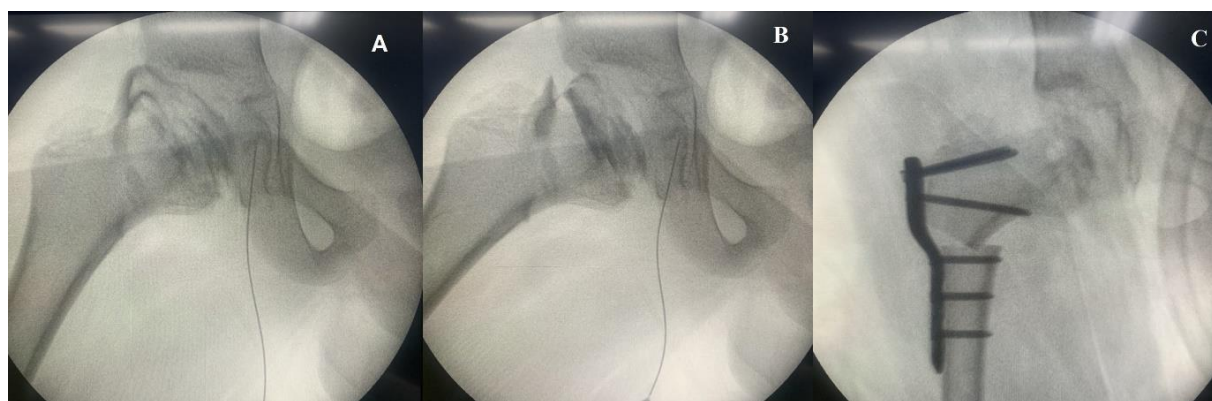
(A) Arthrogram showing lateral subluxation findings of Legg-Calve-Perthes disease of the right hip in a 7-year-old boy. (B) AP radiograph obtained at 30° of hip abduction showing adequate femoral head containment and disappeared lateral subluxate. (C) Image showing femoral varus osteotomy using a locking compression plate.
